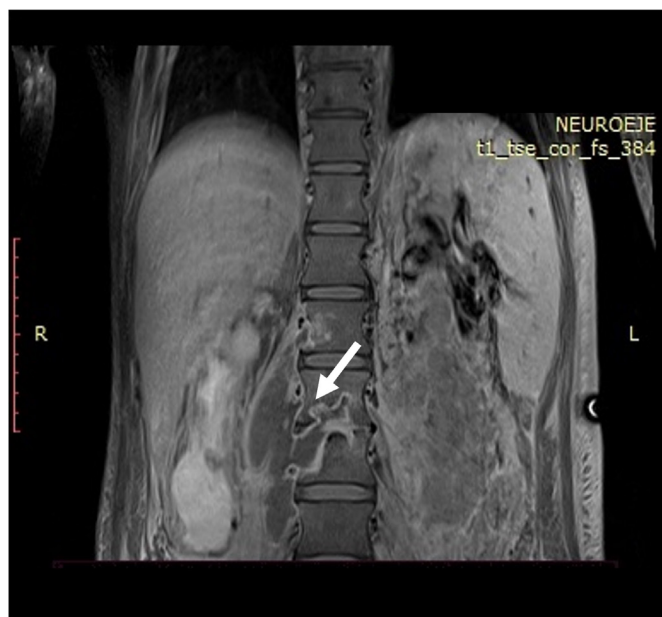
MRI of the lumbar spine showed extensive lesions in vertebrae L2-L3 that invade adjacent soft tissues (arrow) compatible with Pott's disease due to *Mycobacterium bovis*.
